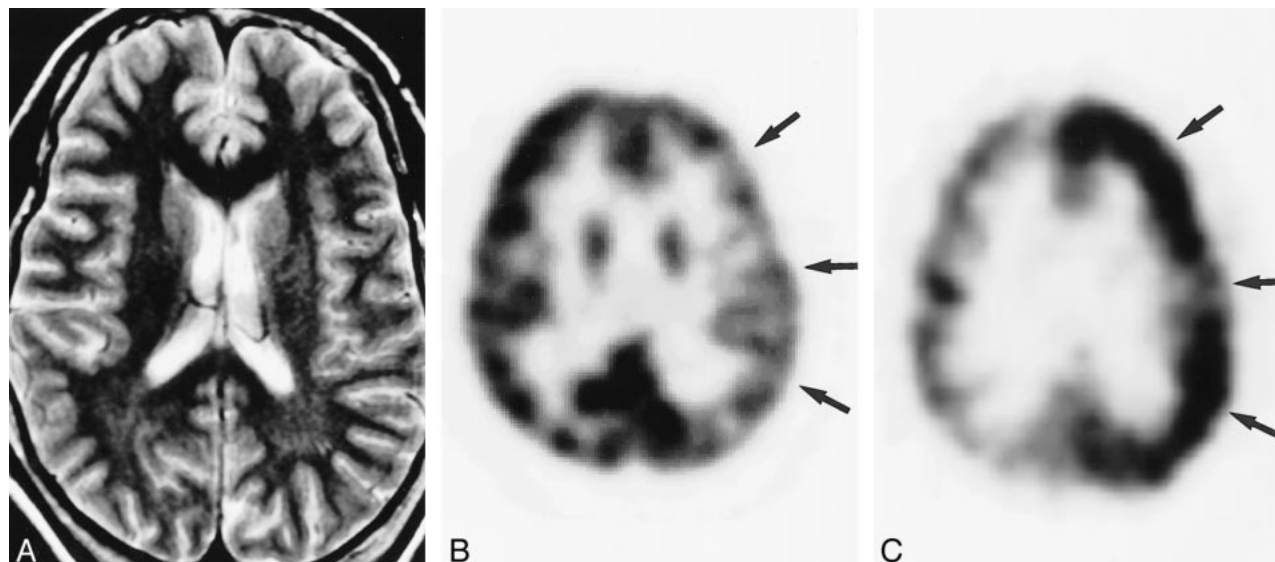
False-negative MR imaging finding for a 24-year-old woman with left frontal lobe epilepsy.
